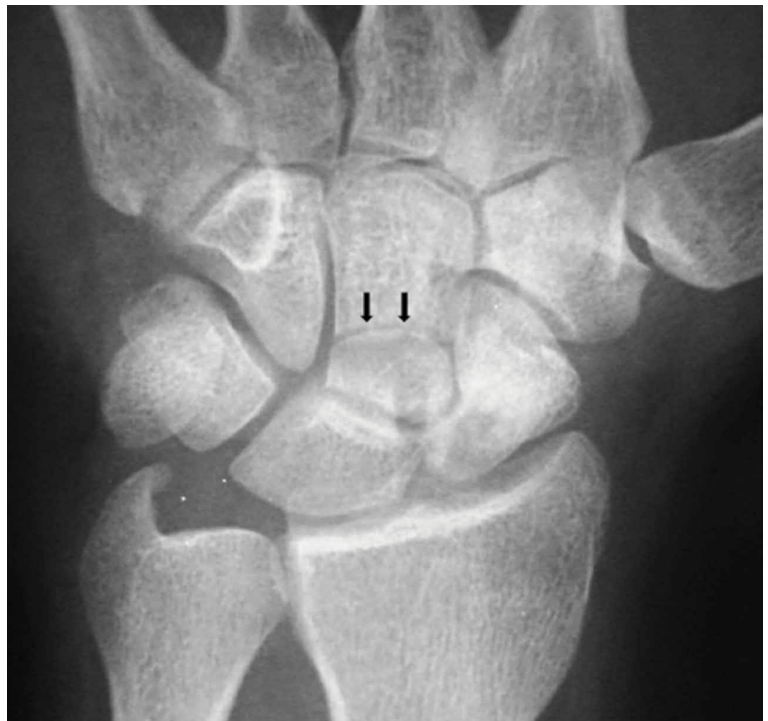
Anteroposterior radiograph of the right wrist shows a fracture of the capitate with the fracture line (black arrows) extending proximally to the waist of the capitate.
